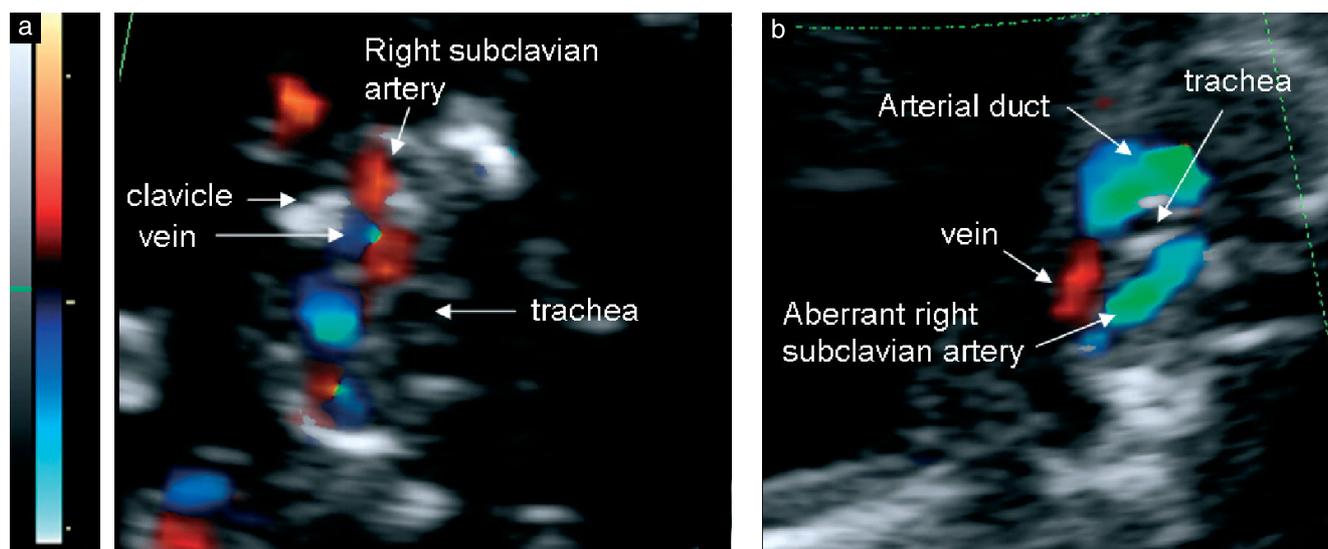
Ultrasound images showing (a) normal right subclavian artery coursing in front of the trachea, towards and underneath the right clavicle with the accompanying vein and (b) aberrant right subclavian artery arising from the junction of the aorta with the arterial duct crossing behind the trachea towards the arm; the accompanying vein is also seen.
